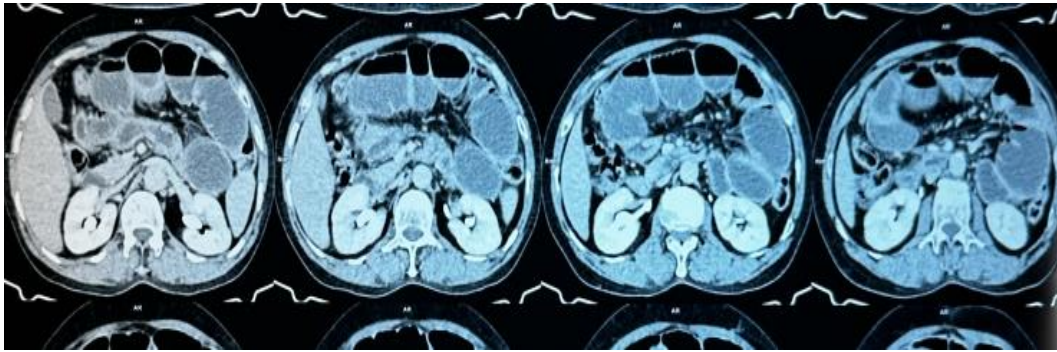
The similar findings in axial section of CT abdomen and pelvis
